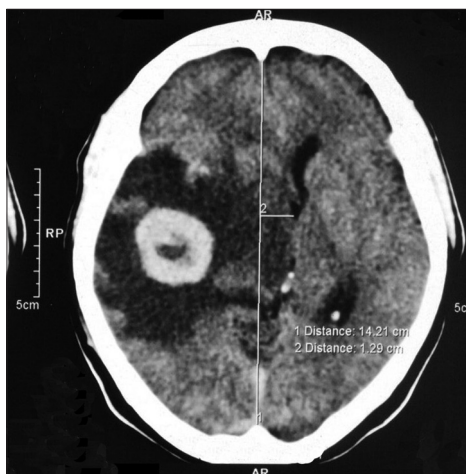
CT-scan brain showing brain metastases
